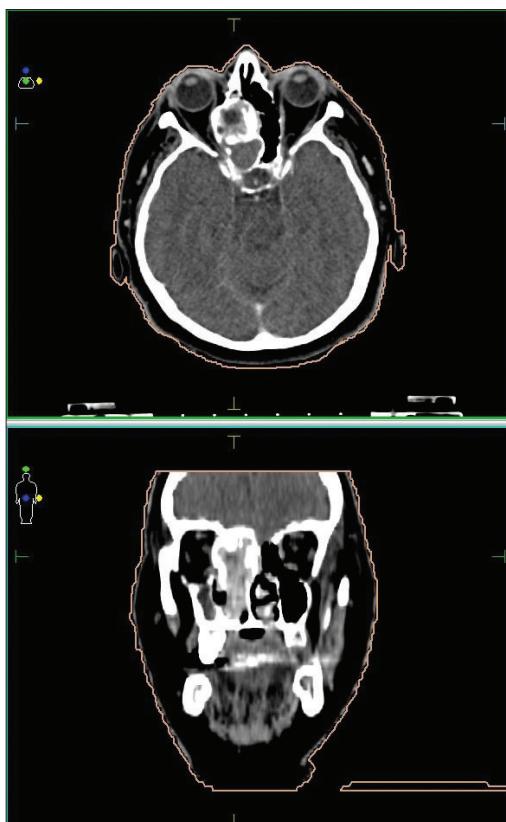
Tumor – Initial CT findings of the head and facial region
